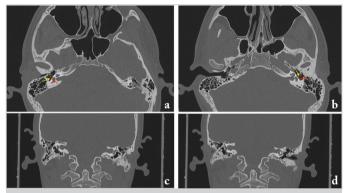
Case A: Right (a–c) and left (b–d) axial and coronal CT scans of the temporal bone showing the bilateral agenesis of the stapes (yellow arrow), the absence of the oval window, and the abnormal position of the facial nerve (red arrow); other ear structures appear normal
